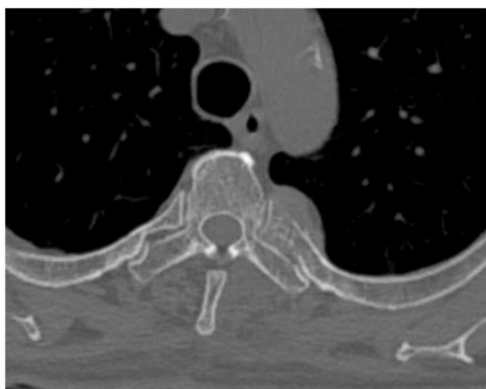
CT image of the fourth left rib. The tumor occurred in the neck of the rib and showed bony disruption with a slight cortical disruption.
